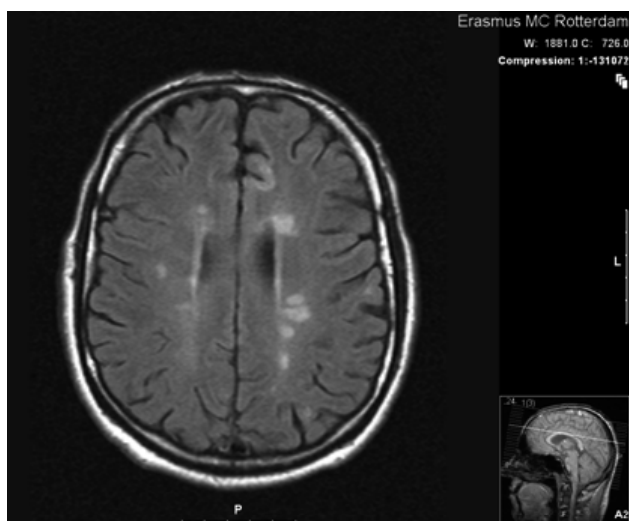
MRI image of a MScl patient, with MScl plaques highlighted.
